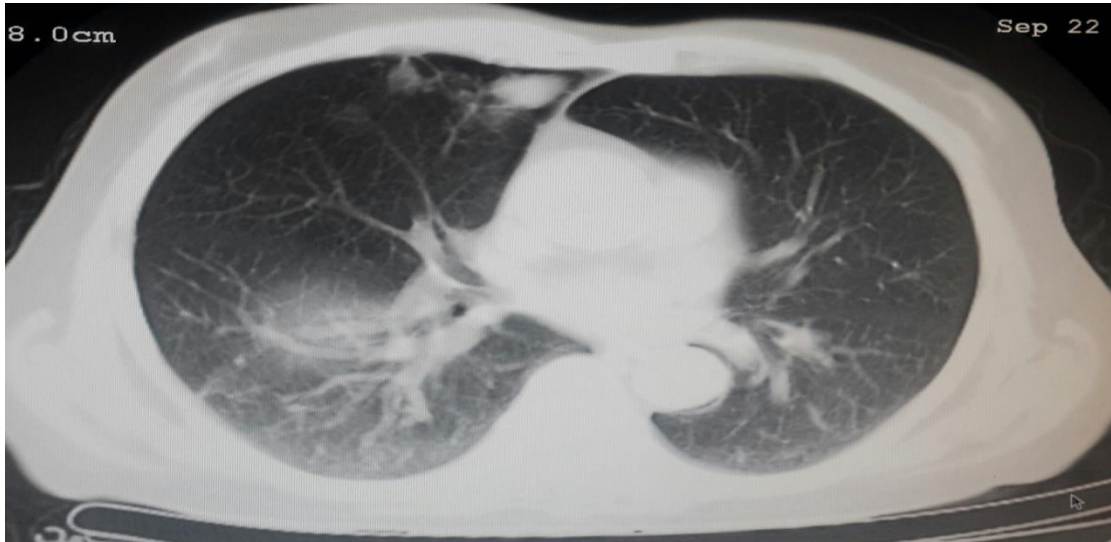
CT chest for male 68 shows TB
